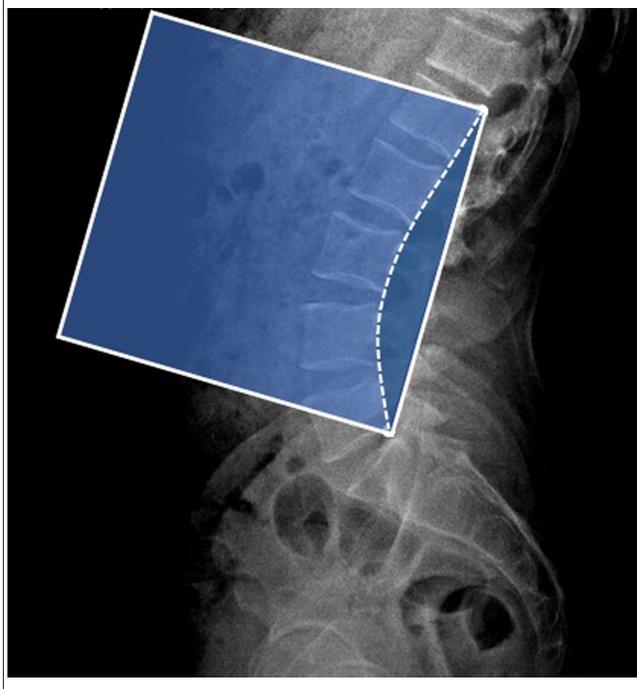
Lateral digital radiograph showing the semilunar area drawn for the estimation of the projection area per length squared.
